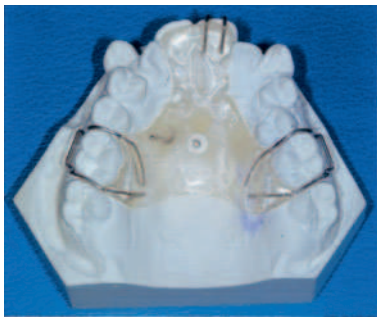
Radiographic stent on working model
